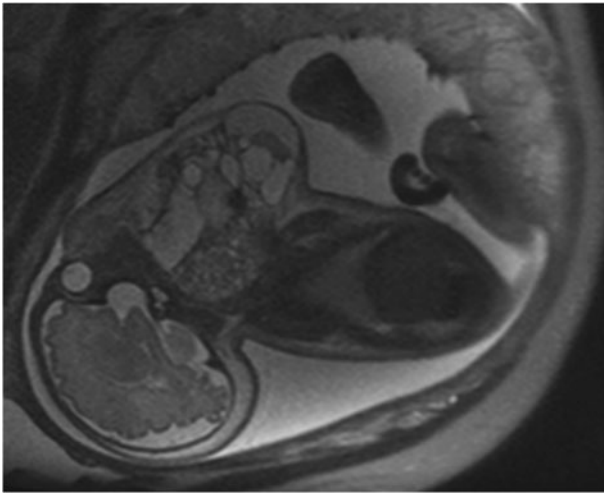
A T2-weighted fetal magnetic resonance imaging scan conducted at 34 weeks and 5 days gestational age demonstrates polyhydramnios and a large midline complex mass, measuring $14 \times 13 \times 10$ cm, consistent with giant cervicofacial teratoma.
